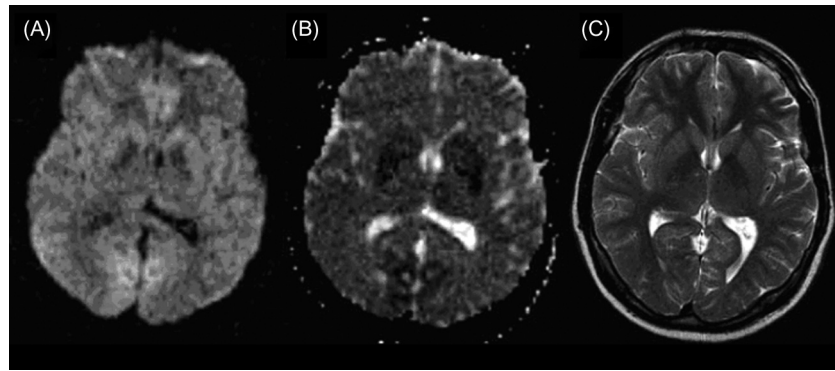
MRI of the brain of a cardiac arrest patient with excellent recovery. Whereas standard T2-weighted MRI (Figure 20.4C; compare to Figure 20.3) did not reveal any abnormalities, diffusion-weighted MRI in the acute phase (15 h after resuscitation) revealed MRI abnormalities that are compatible with bilateral brain damage. These are shown in Figure 20.4A and consist of bilateral hyperintense damage in proximity to primary visual cortex and the optic radiation (compare also with Figure 20.3D). In addition, the apparent diffusion coefficient (ADC; Figure 20.4B) maps showed prominent signal decrease in the same locations as DWI, compatible with ischemic brain damage. Source: Modified from Els et al. (2004) with permission from Blackwell Publishing.
